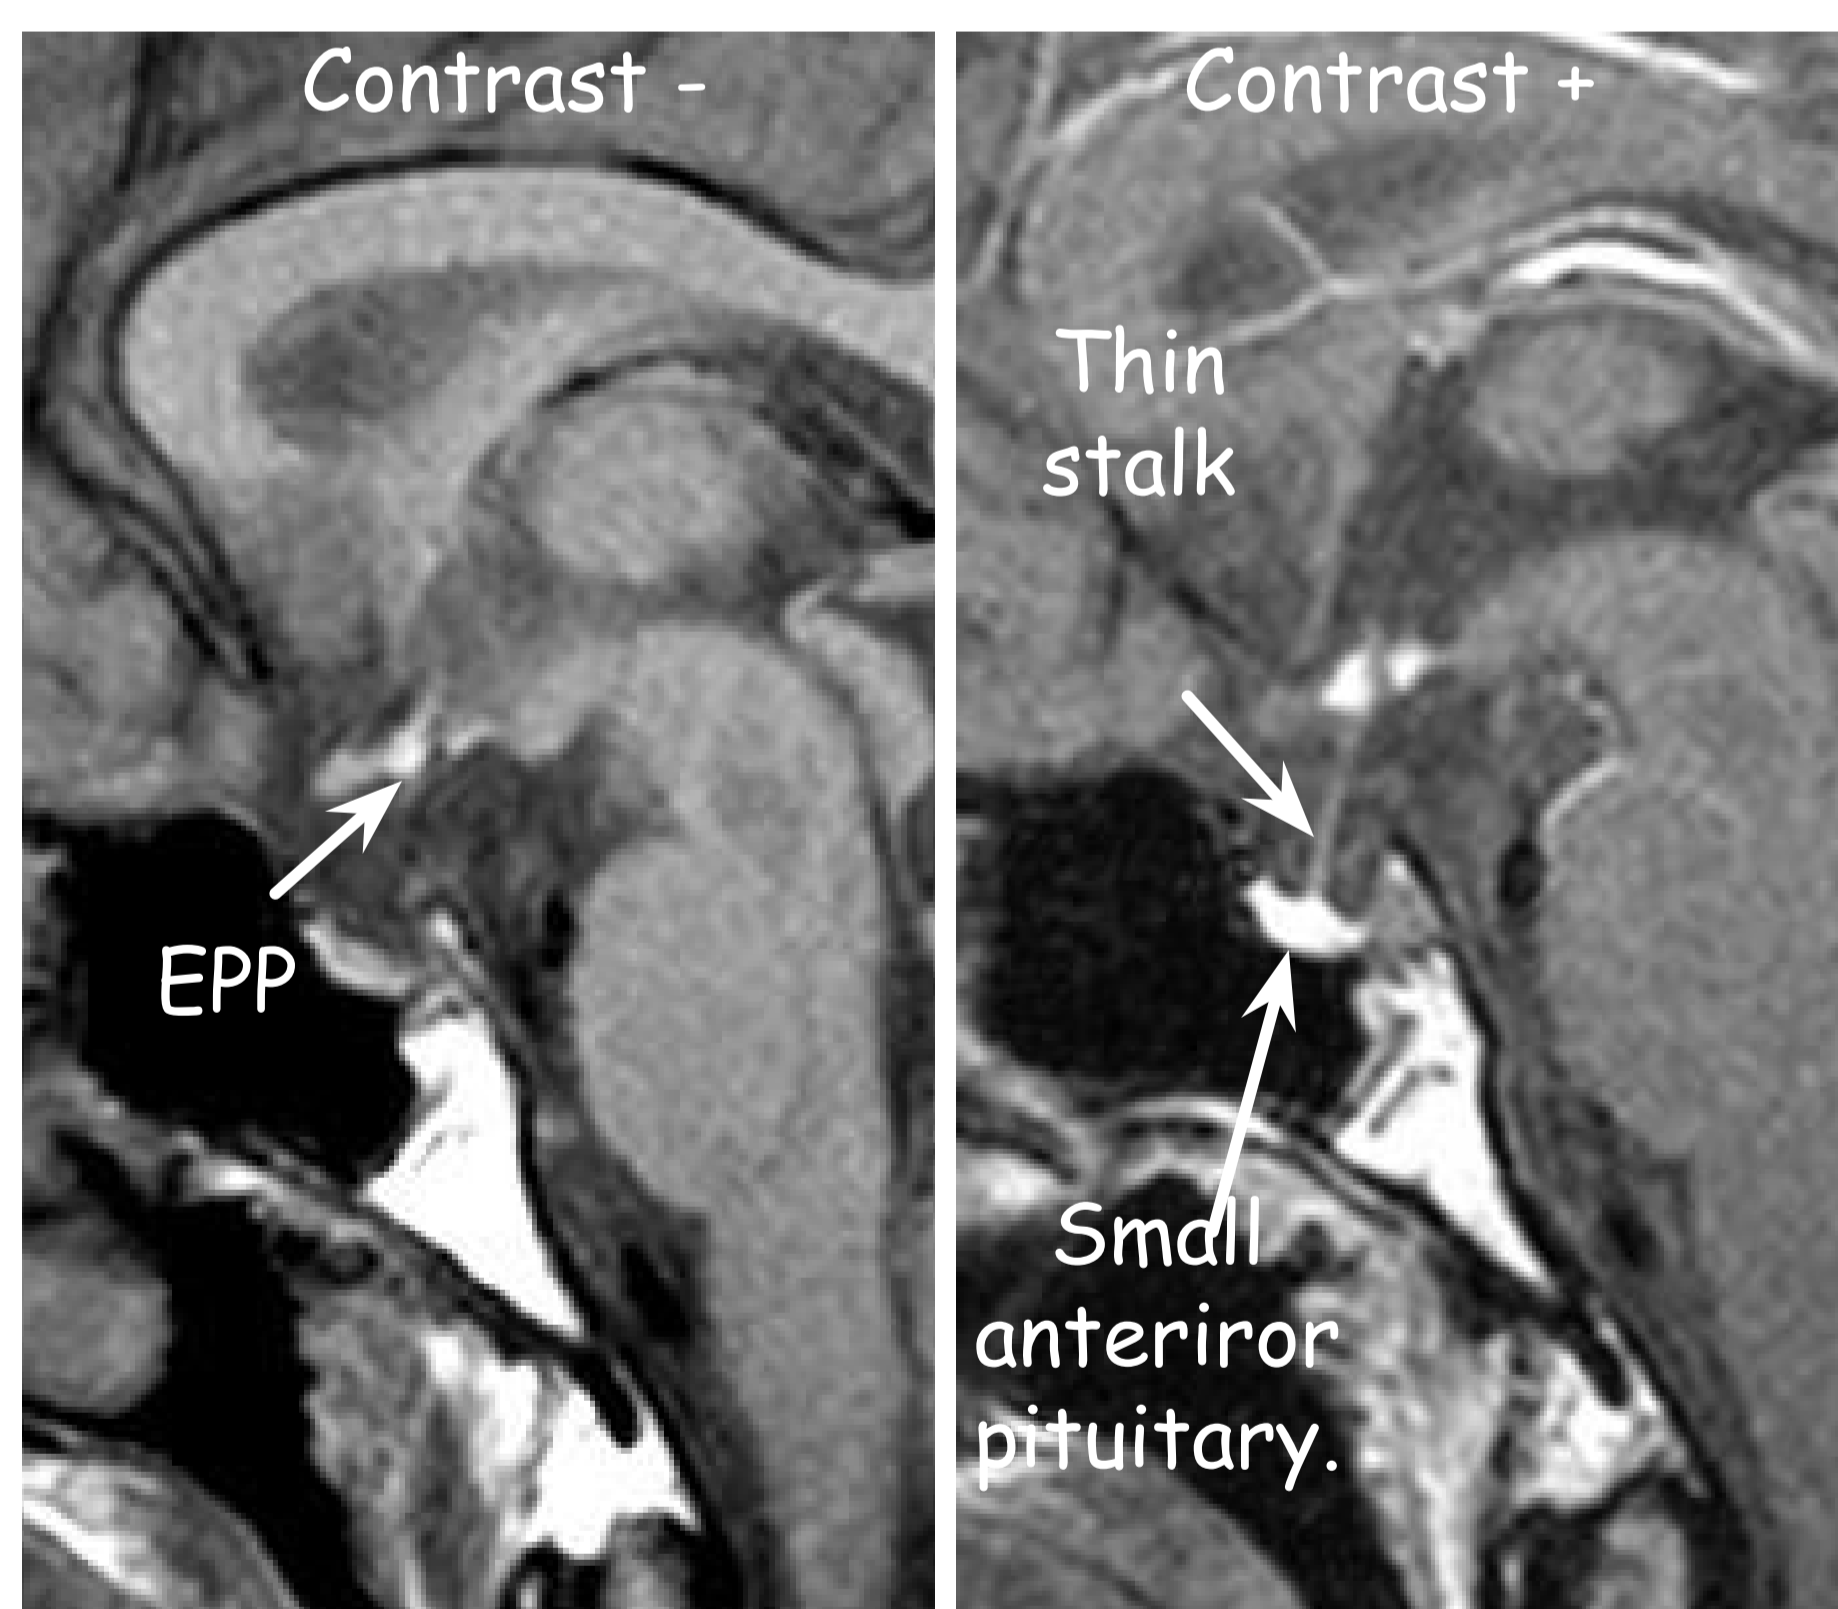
Magnetic resonance imaging (sagittal T1 images)
